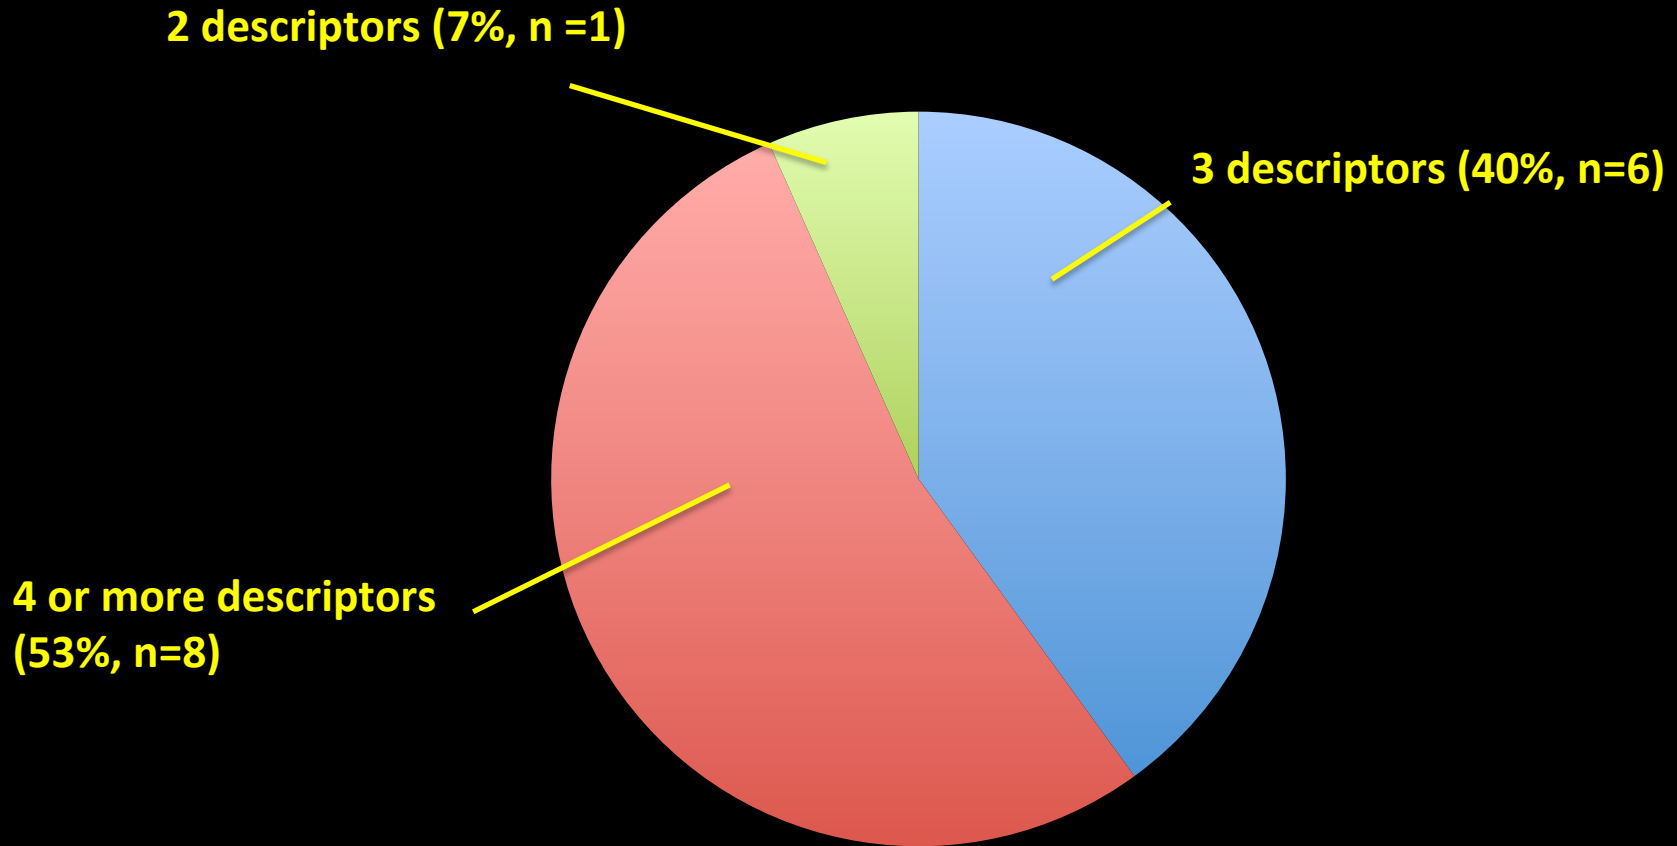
Number of suspicious descriptors for BI-RADS 5 patients who underwent diagnostic ultrasound only (n=15)
